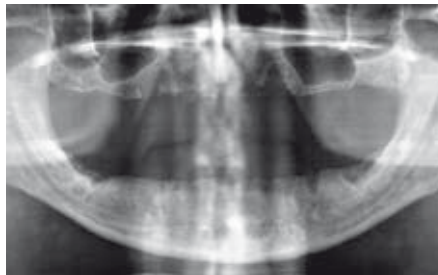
Panoramic radiograph after tooth extraction.
